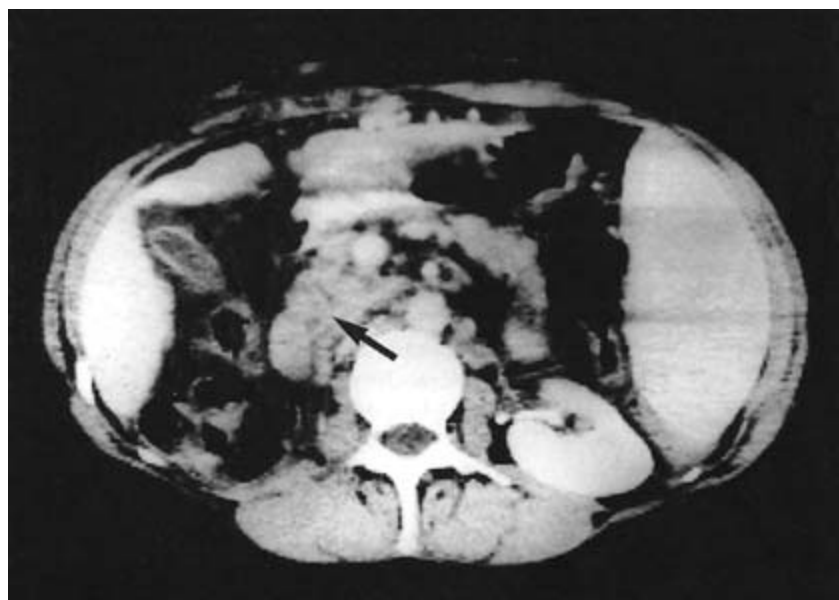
Contrast-enhanced CT scan from a patient with chronic sarcoidosis showing retroperitoneal lymphadenopathy (arrow).
